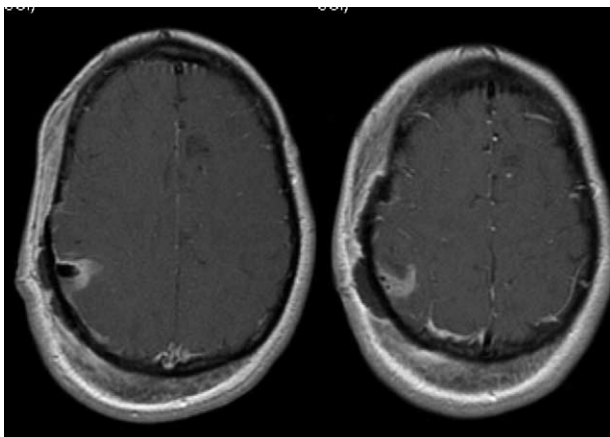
Postoperative axial T1-weighted MRI scans with gadolinium, showing complete resection of the right temporal-parietal lesion.
